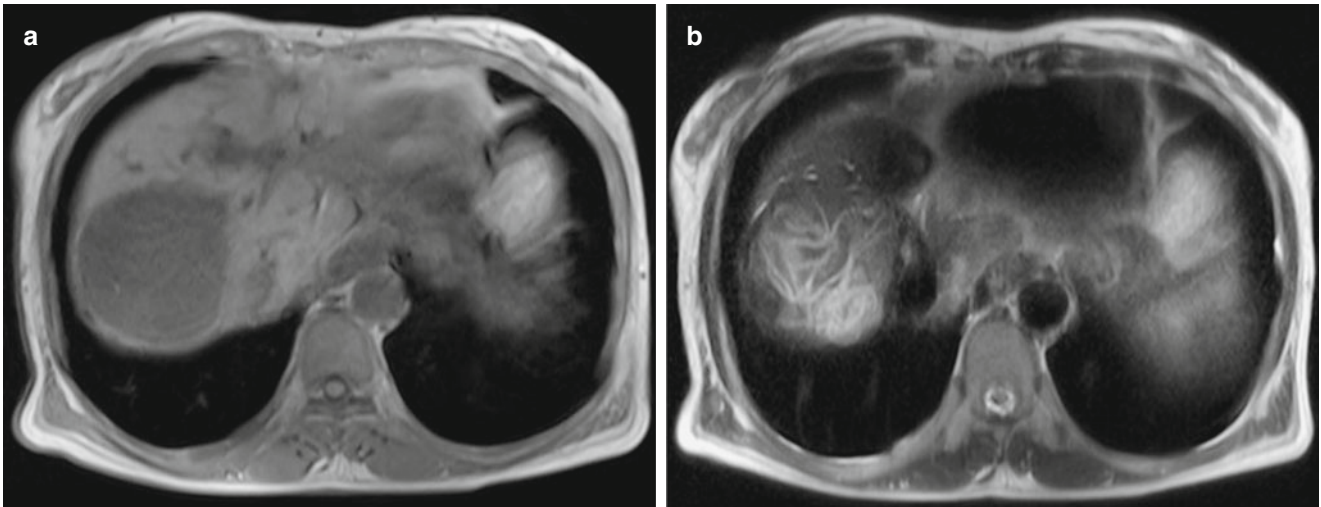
Hepatic alveolar hydatidosis. (a, b) MR imaging demonstrates round-like lesion in the liver, with low signal by T1WI, uneven signal by T2WI, and observable ribbon sign
